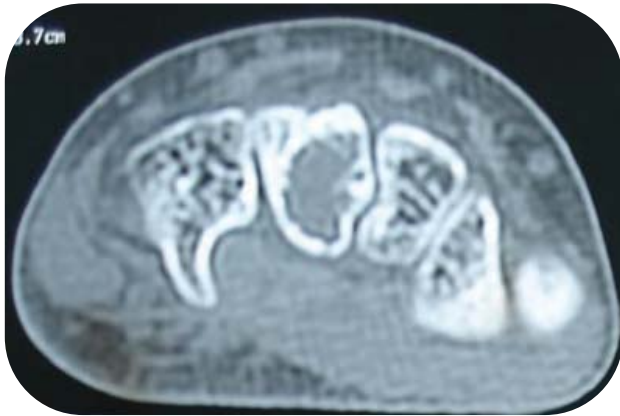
CT Scan wrist showing lytic lesion in Capitate
